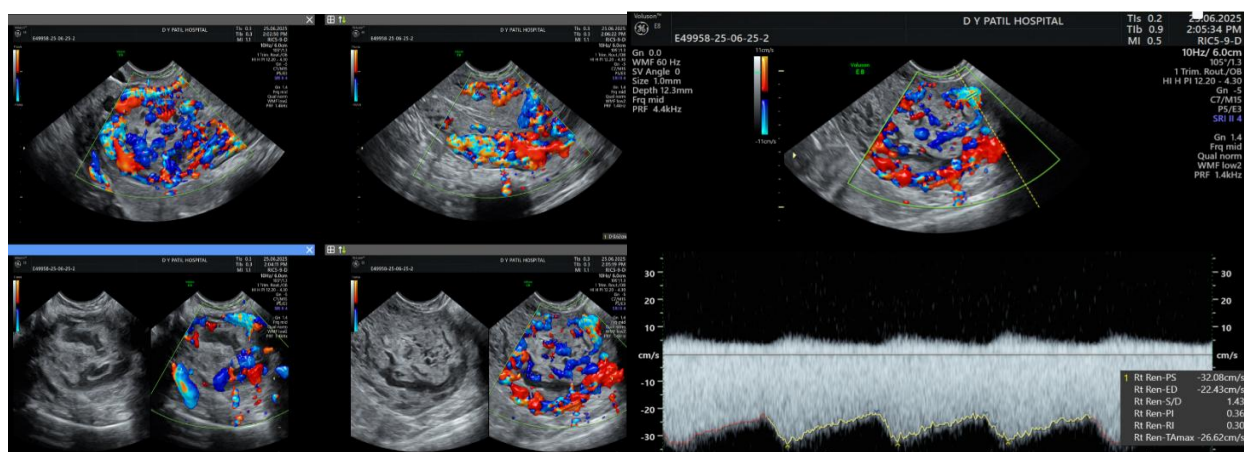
On colour doppler, intense vascularity was seen involving the myometrium and the entire echogenic lesion with features suggestive of low resistance flow (PSV value of 32.0 cm/sec with RI of 0.3).
